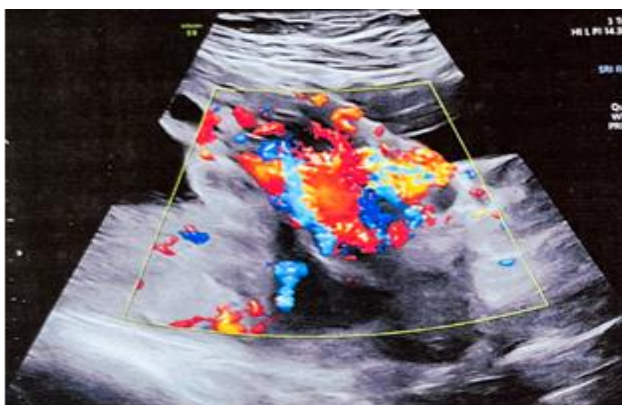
Colour Doppler showing marked placental hypervascularity with bridging vessels consistent with PAS.
